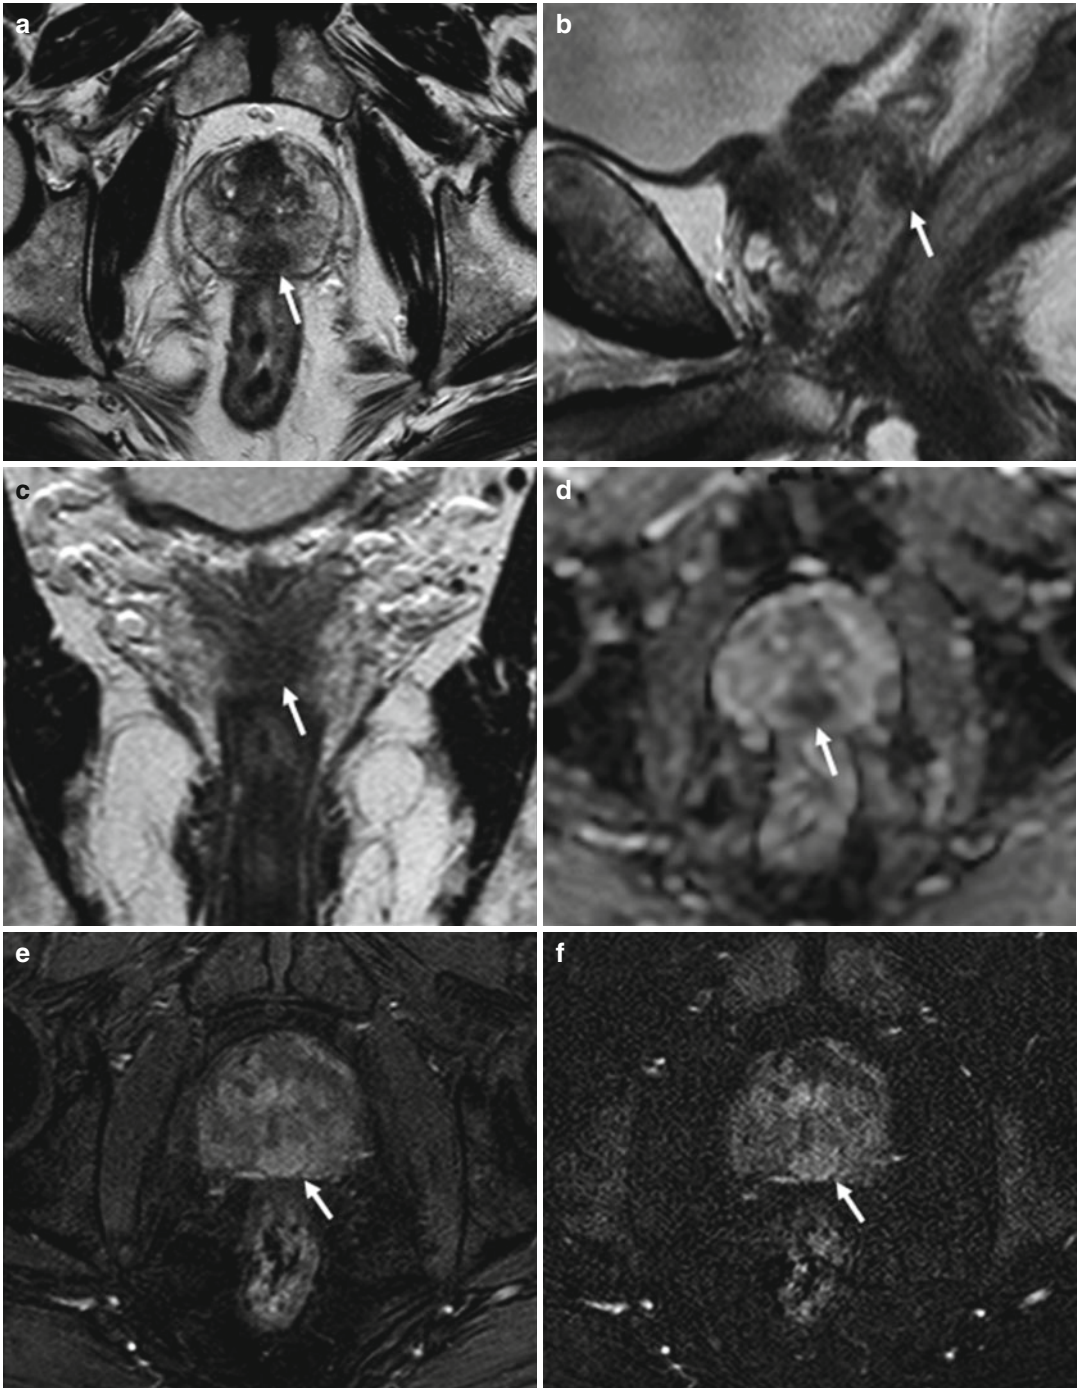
(a–f) 74 years old, PSA 8.2 ng/ml, Gleason 9 (4+5). Axial (TR: 4074; TE: 100) (a), sagittal (TR: 4006; TE: 100) (b), and coronal (TR: 4013; TE: 100) (c) T2-weighted sequences show a hypointense nodule (arrows), with major axis of 18 mm, at the middle third, posteriorly and medially, involving both lobes. On ADC sequence (d), the nodule (arrow) appears hypointense, while on post-contrastographic phase (e) and subtractive
